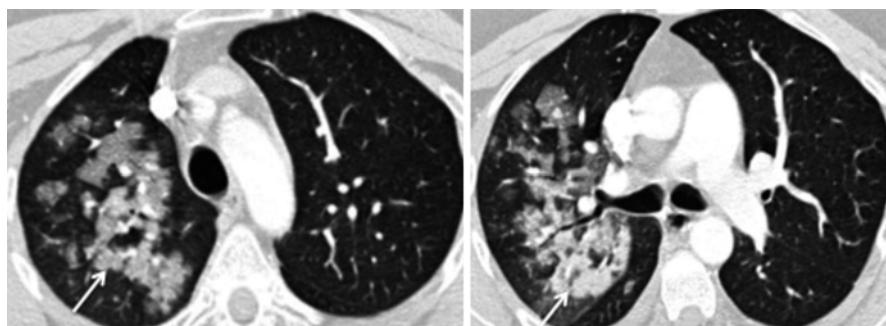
A 51 year-old male with Wegners syndrome presented with acute haemoptysis. Axial CT images on lung windows demonstrate rather dense right-sided consolidation and ground glass opacification (*white arrow*) due to pulmonary haemorrhage. The left lung is clear
